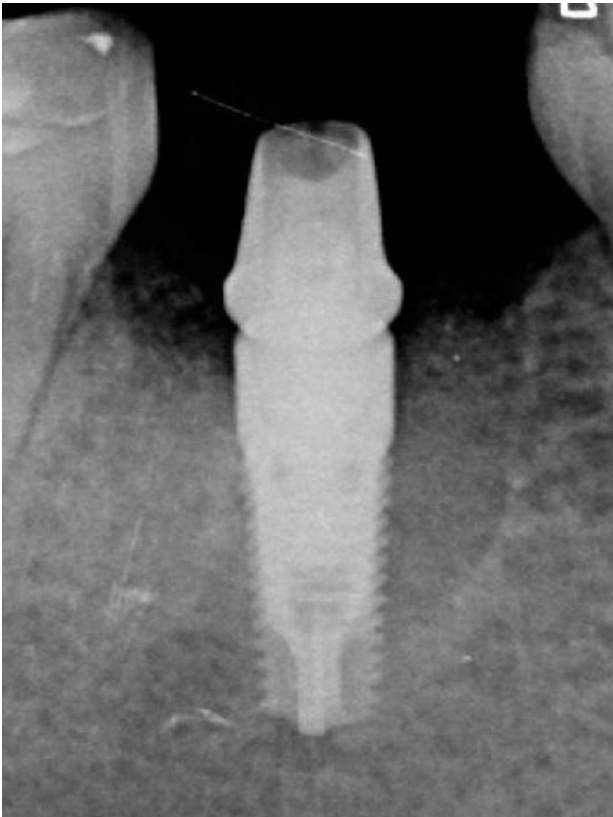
c. *Abutment screwed up in the implant: monitoring intraoral radiography.*
